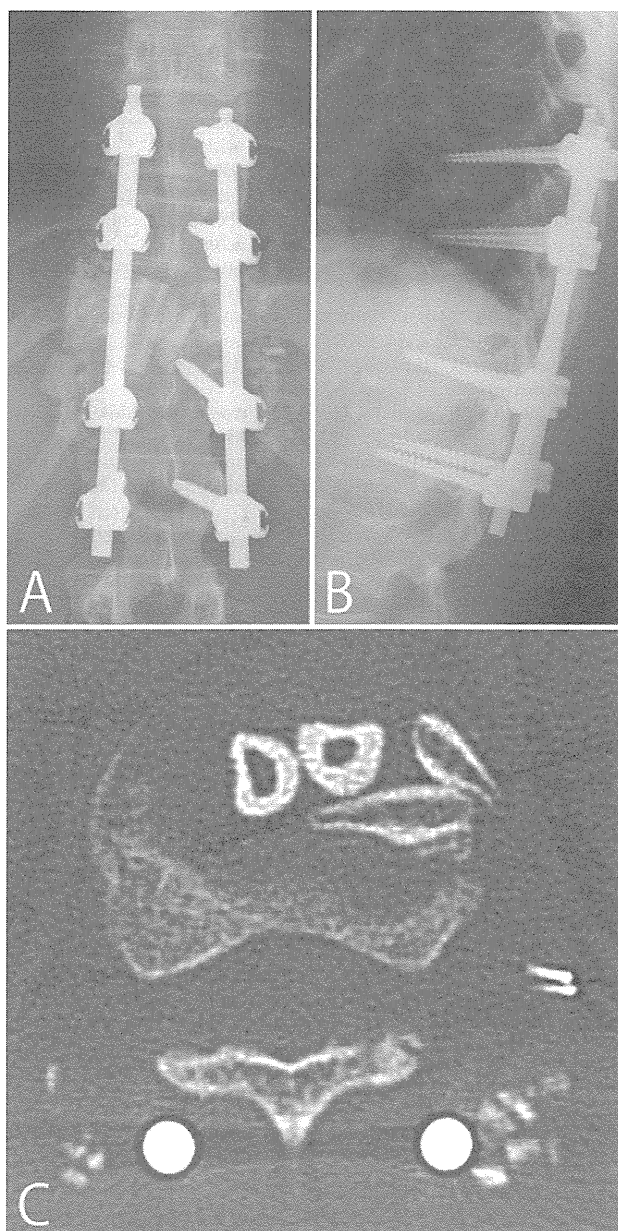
Postoperative plain radiographs (A and B) showing improved local kyphosis (Cobb angle 10°). Axial CT image (C) showing the position of the rib and fibula graft positioned in the patient.
